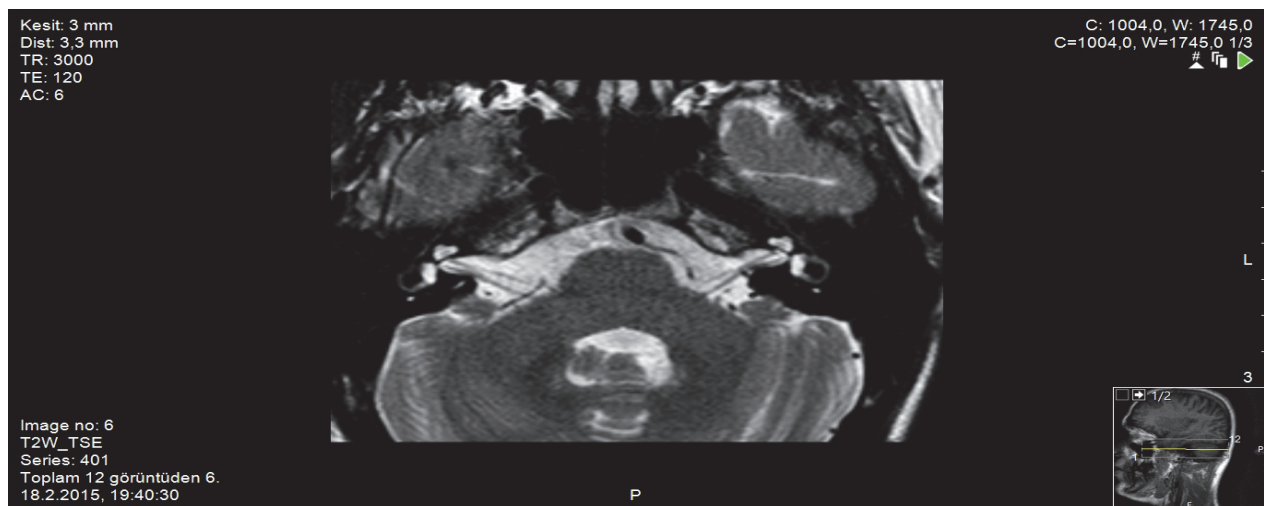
Normal temporal and cranial Magnetic Resonance Imaging were detected in the patient.
